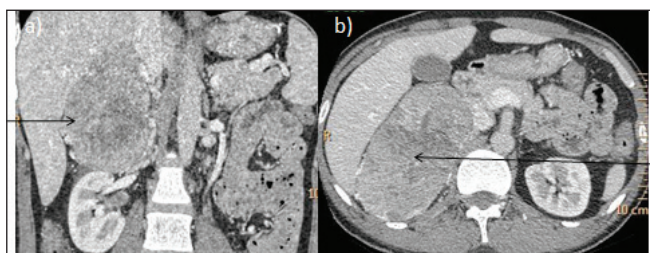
Contrast enhanced CT scan of abdomen showing a large heterogeneously enhancing mass with central necrosis with arrow pointing at the mass in the coronal (a) and axial images (b) arising from the right adrenal gland.
